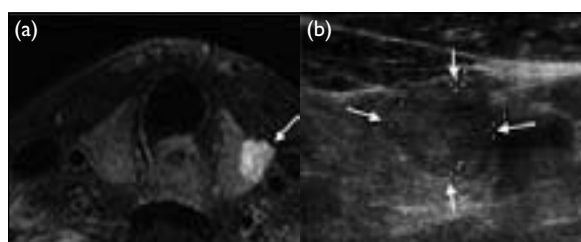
(a) Axial T2-weighted image of the thyroid gland showing a well-defined hyperintense focal lesion in left lobe. (b) Corresponding axial ultrasound scan at the same level reveals a slightly hypoechoic mass in the left thyroid lobe
